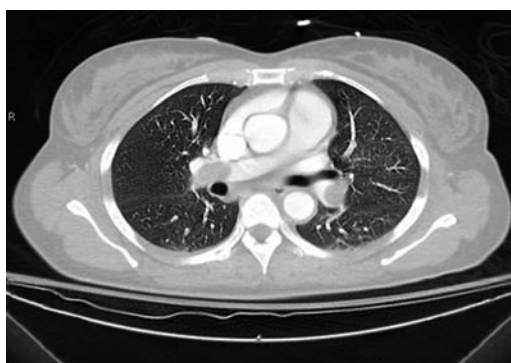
Contrast-enhanced CT of the chest showing pulmonary emboli at the subsegmental level of the right and left pulmonary arteries.
